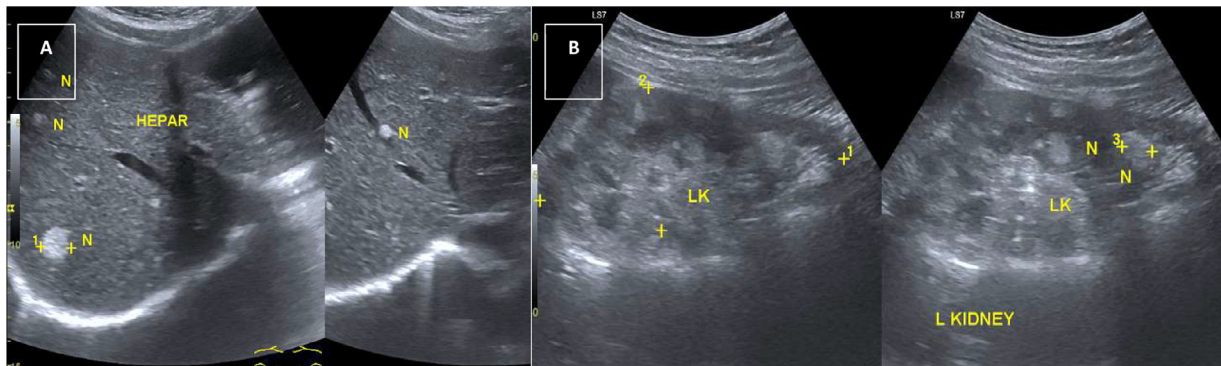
Ultrasound findings of the liver and kidneys. (A) Multiple hyperechoic lesions were found across the liver parenchyma, consisting of fat density. (B) Both kidneys showed multiple scattered hyperechoic lesions at the renal parenchyma, which can be correlated with fat nodules.
